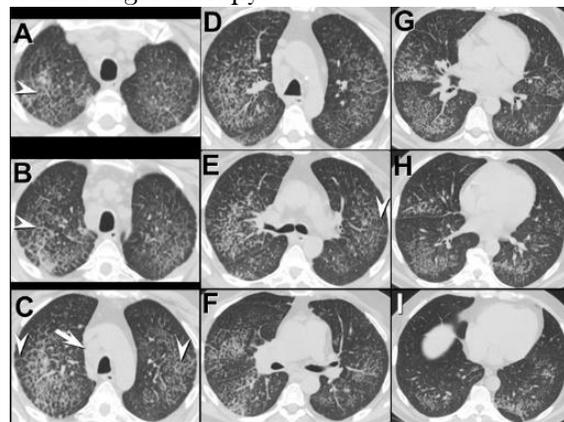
Axial unenhanced CT obtained 7 months after initial presentation. Click [here](#) to open Figure 5 in a new, enlarged window. Click [here](#) to open a video of Figure 5.
